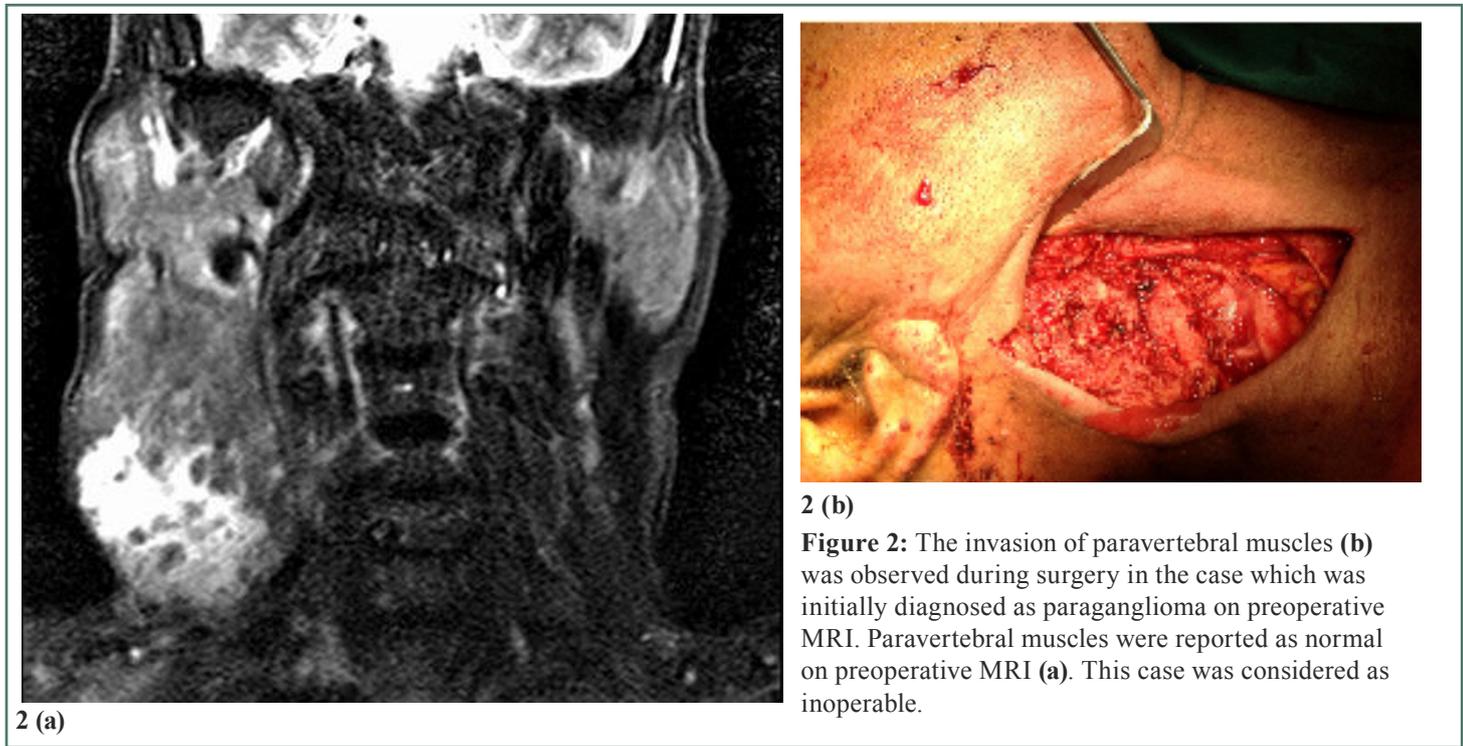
The invasion of paravertebral muscles (b) was observed during surgery in the case which was initially diagnosed as paraganglioma on preoperative MRI. Paravertebral muscles were reported as normal on preoperative MRI (a). This case was considered as inoperable.
